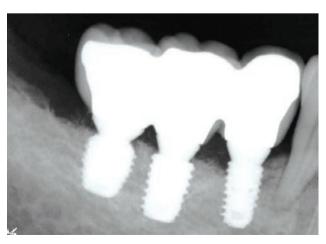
Periapical radiograph of right mandibular molar site after completion of implant prosthesis. TSIII Ultra-Wide(6D/6L) on #47, TSIII SA(#45:4D/7L, #46:5D/7L) on #45 and 46 have been installed.
